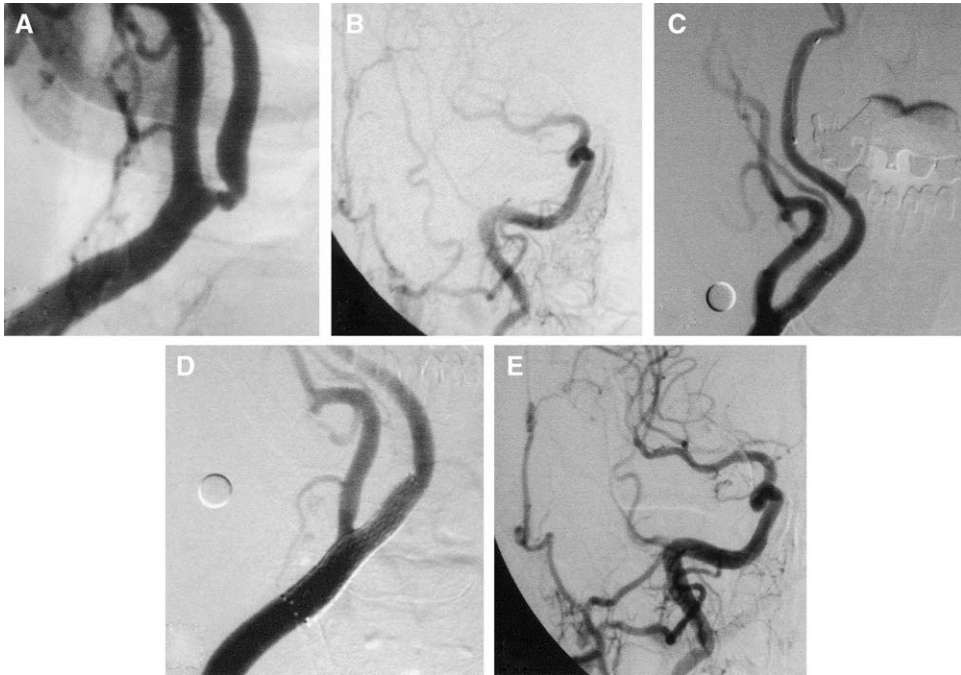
This 86-year-old woman presented with progressively increasing Doppler ultrasound velocities in the right carotid artery. (A) Cerebral angiogram demonstrating the presence of a severe stenosis involving the origin of the right internal carotid artery (ICA). Because of her age (>80 years) and the fact that the lesion extended up to the body of C2, she was enrolled in the Carotid Revascularization with ev3 Arterial Technology Evolution (CREATE), a high-risk population carotid revascularization registry. (B) Intracranial image, frontal view, revealing delayed filling of ICA branches (when compared with the external carotid artery) as well as lack of filling of the anterior cerebral artery territory. (C) Right carotid artery stenting was performed using a combination of a Spider distal embolic protection device (ev3; Plymouth, Minnesota) and a Protégé Stent (ev3). Angiographic image after stenting demonstrates excellent revascularization of the vessel (D), with improvement of flow to the intracranial circulation (distal ICA branches filling before distal external carotid artery branches; anterior cerebral artery filling) (E).
